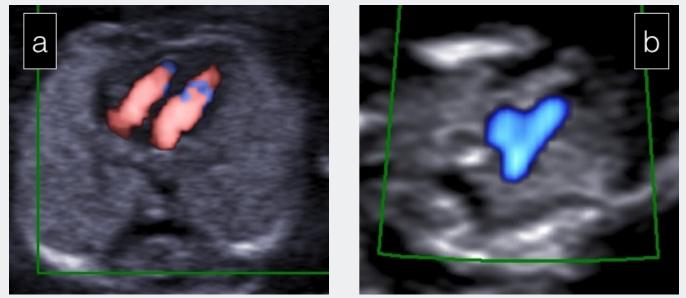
Early fetal echocardiography using Color Doppler energy mode by visualizing the four chamber (a) and three vessel tracheal (b) views.
